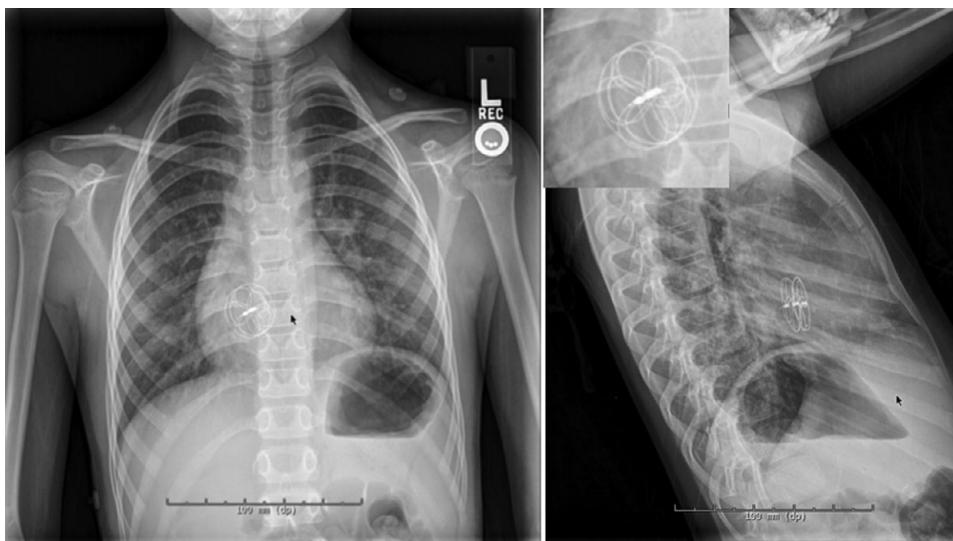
Chest X-ray demonstrating an Amplatzer device in situ
